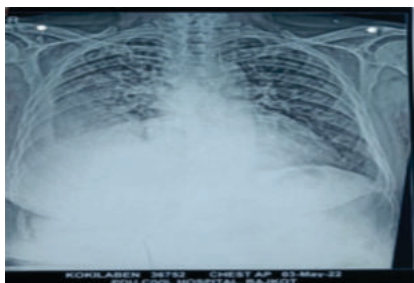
Chest radiography suggestive of right sided midzone and lowerzone alveolar infiltrates with ipsilateral costophrenic blunting suggesting pleural effusion
